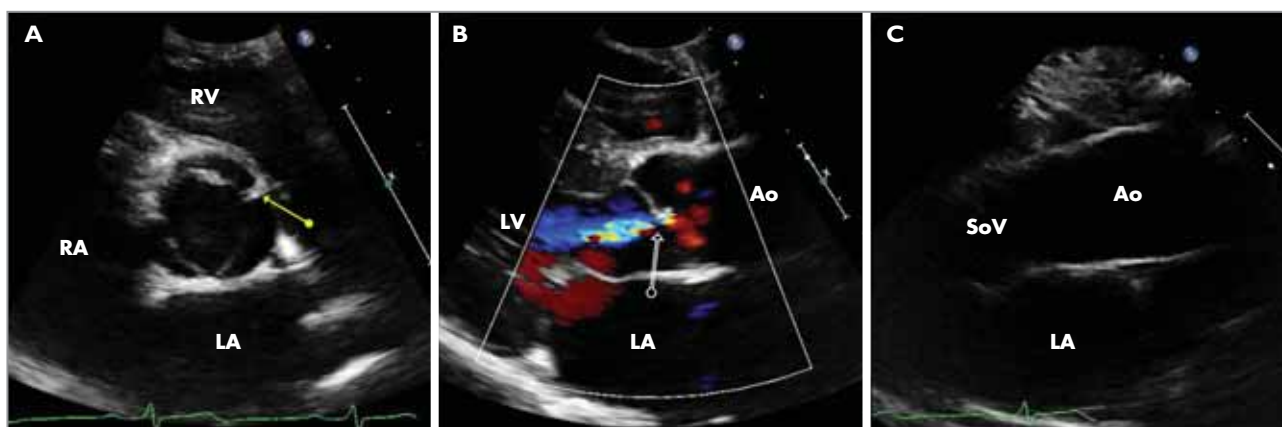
Transthoracic echocardiographic findings in a 19-year-old patient on the spectrum of the bicuspid aortic valve syndrome. A. Short axis of the aortic valve demonstrating partial fusion of the base of the right and left coronary cusps (yellow arrow). B. Colour Doppler in the parasternal long axis showing mild aortic regurgitation. C. Parasternal view of the proximal ascending aorta with a mild dilation of the ascending aorta but normal aortic sinuses and sinotubular junction.
